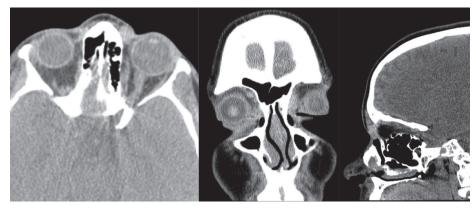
CT scan demonstrating well-circumscribed, soft tissue mass in the left medial canthal region.
